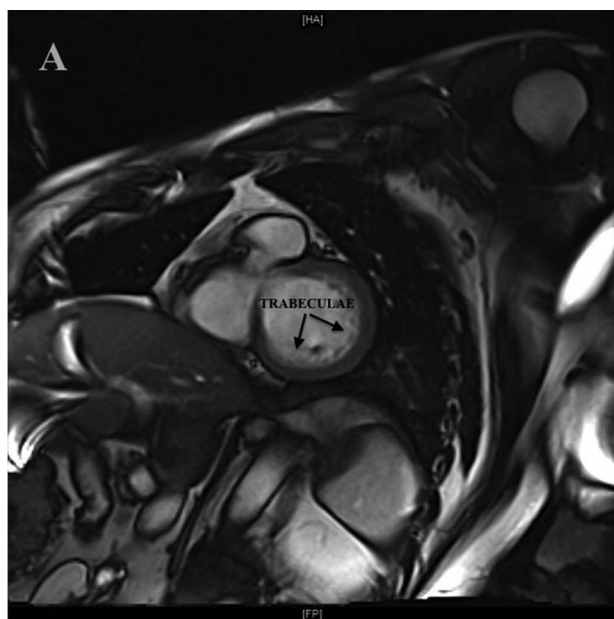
Cardiac MRI of the patient with short axis view of the heart: The left ventricular myocardium is significantly trabeculated with deep recesses extending along the entire cavity of the left ventricle including the apex.
